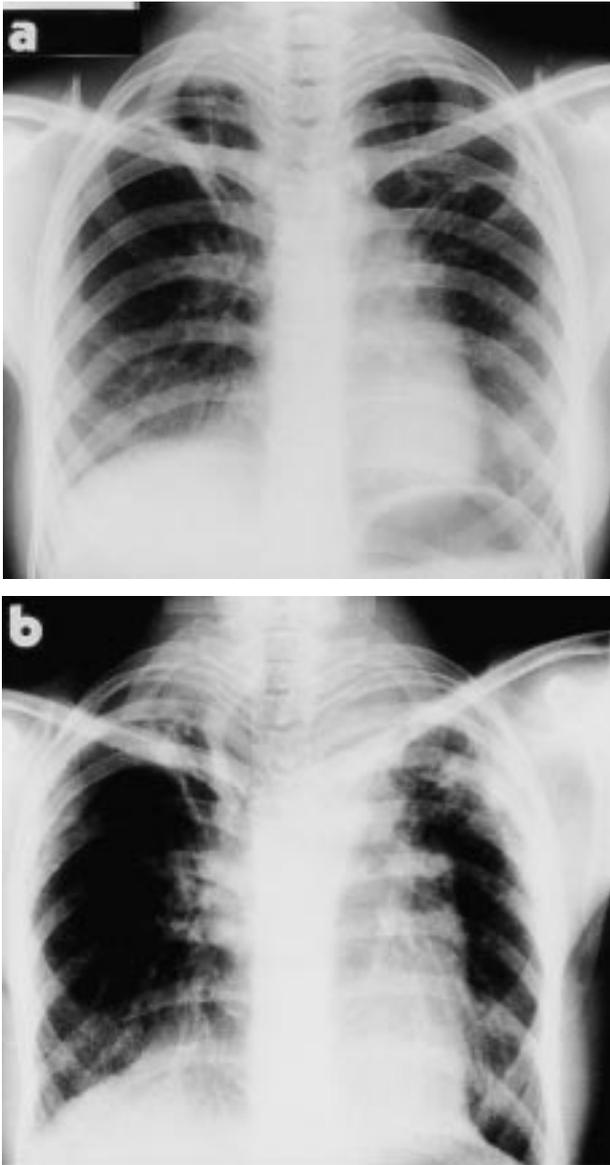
a) Chest radiograph from patient 1 performed in 1981, 3 yrs after the end of treatment for pulmonary tuberculosis, showing mild right upper lung retraction and a small nodule in the upper left lung but no pleural thickening. b) Chest radiograph from the same patient taken in January 1984, showing pleural fibrosis more marked on the left side.
